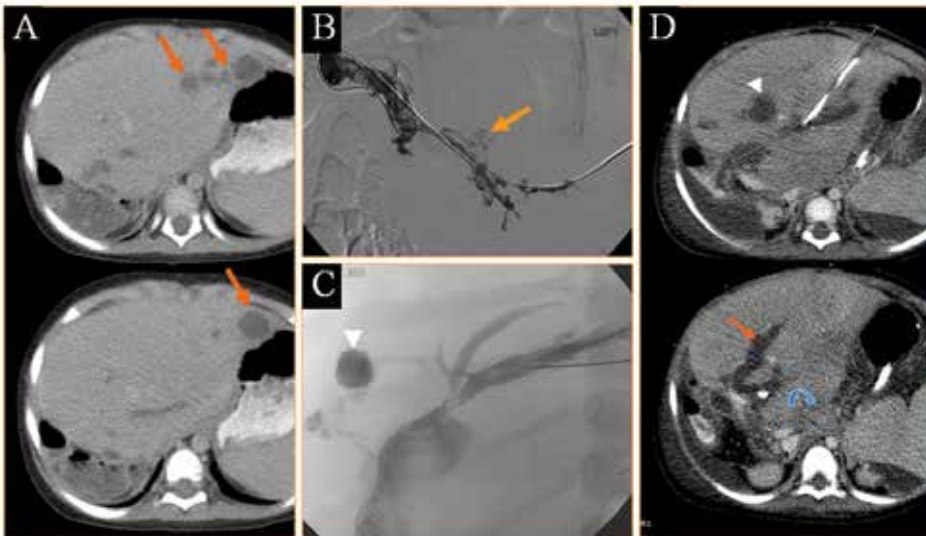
(A) CT showing multiple bilomas (arrows). (B) Percutaneous cholangiogram reveals irregular and dilated bile ducts (arrow) consistent with ischemic injury due to hepatic artery thrombosis. (C) Percutaneous cholangiogram in different duct reveals a small biloma (arrowhead). (D) Follow up CT of the abdomen reveals resolving bilomas with draining catheter in site (arrow). Retroperitoneal lymphadenopathy (curved arrow) consistent with post transplant lymphoproliferative disorder (PTLD)
